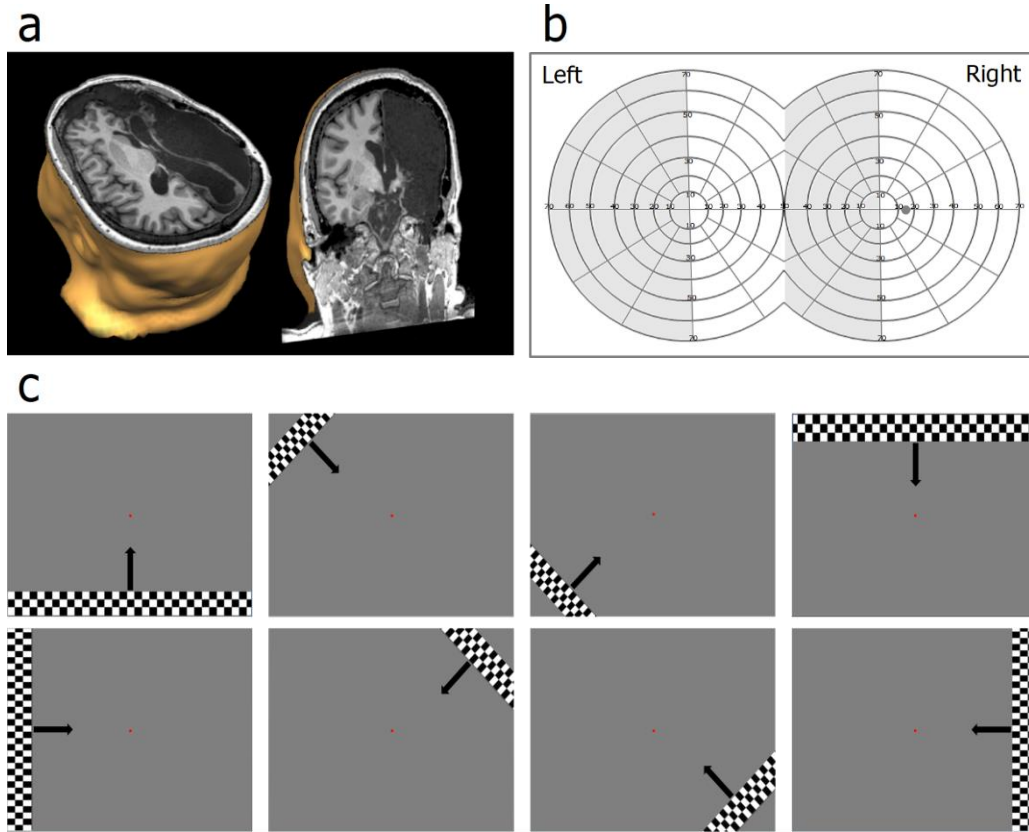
Patient DR T1-weighted MRI, Perimetry, and Stimulus
